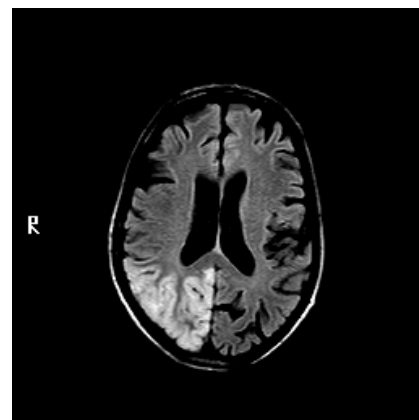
Axial fluid attenuated inversion recovery (FLAIR) image of the patient's brain, obtained in December 2007. While this image initially was interpreted as evidence of a right posterior cerebral artery (PCA) stroke, note that the area of signal abnormality extends farther anteriorly than the typical PCA distribution—into what is usually middle cerebral artery territory. Typically, stroke-like episodes in mitochondrial myopathy, encephalopathy, and lactic acidosis with stroke-like episodes (MELAS) syndrome are associated with imaging abnormalities that do not conform to a vascular distribution and most often are located in the posterior brain.
